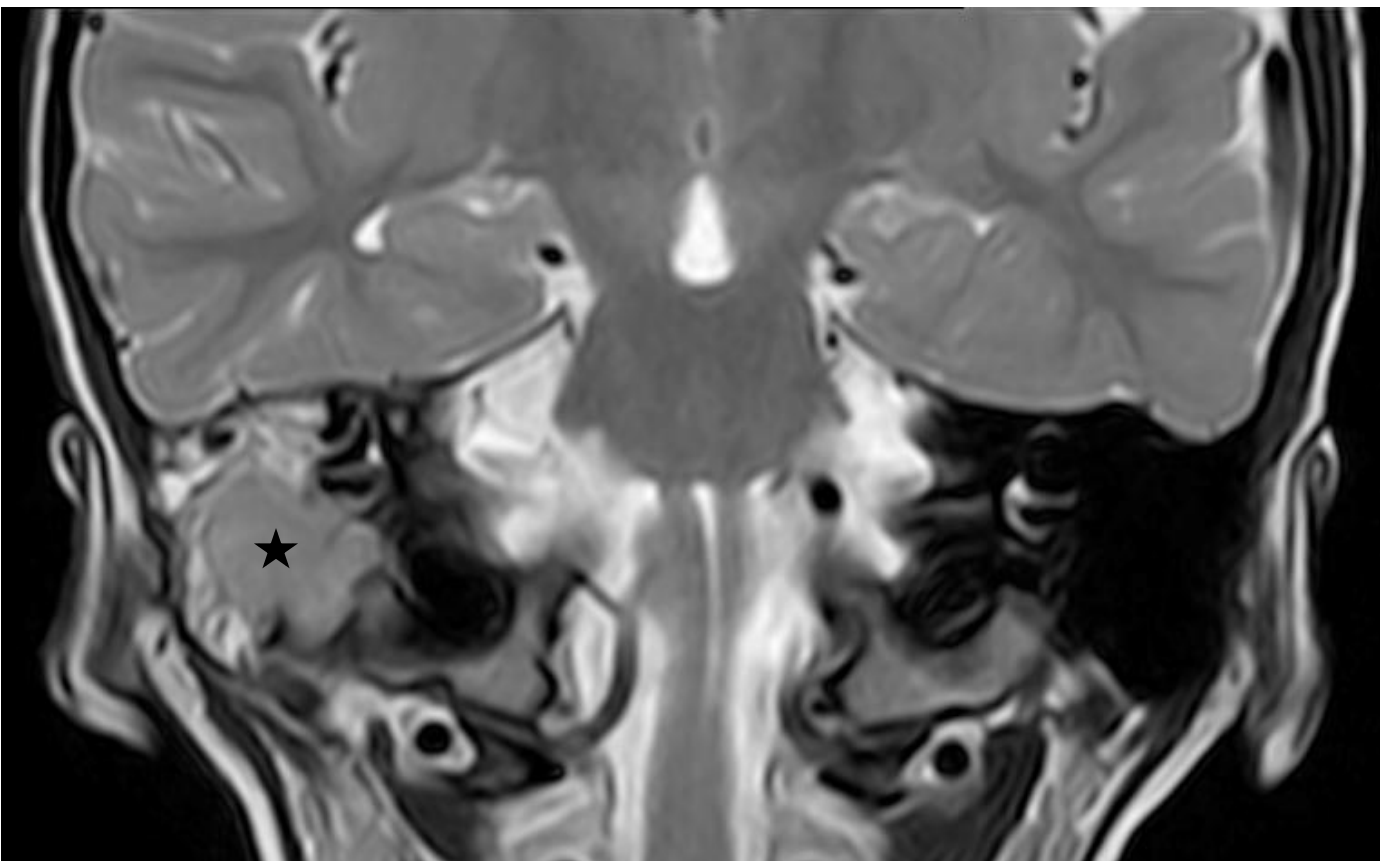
(★) Right mastoid lesion in T2 sequence in MRI.
